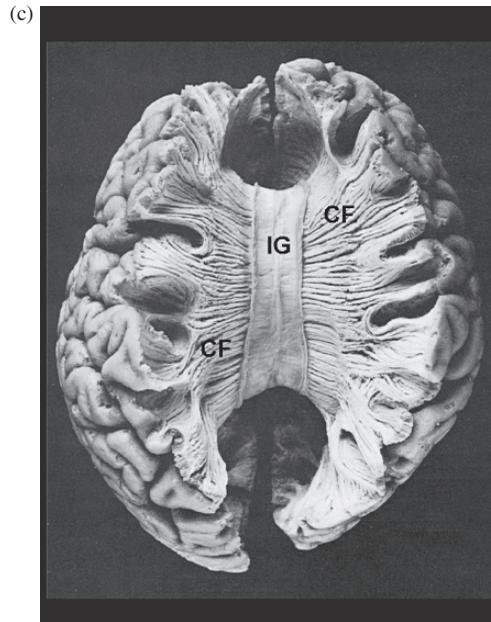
Corpus callosum as seen on (a) midsagittal brain section, (b) axial views MRI image, and (c) blunt dissection. Abbreviations: CCb, CCg, CCr, and CCs represent the body, genu, rostrum and splenium of the corpus callosum, respectively; CF, commissural fibers; IG, indusium griseum. Brain image was adapted from the *Interactive Brain Atlas* (1994), courtesy of the University of Washington. Blunt dissections (c) of the brain from Gluhbegovic, N. and Williams, T.H. (1980). Used with permission.
